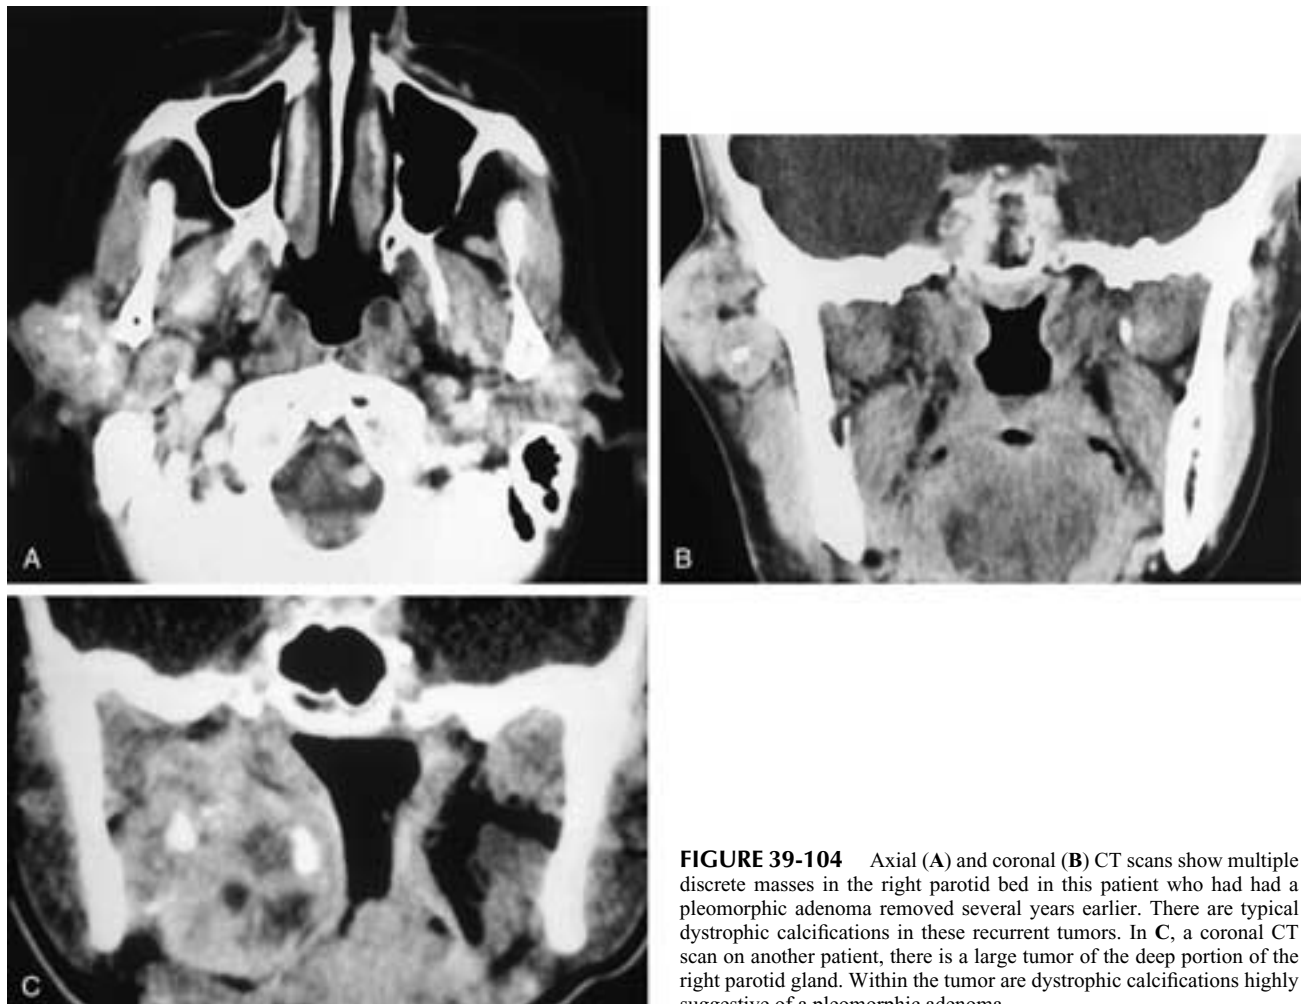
Axial (A) and coronal (B) CT scans show multiple discrete masses in the right parotid bed in this patient who had had a pleomorphic adenoma removed several years earlier. There are typical dystrophic calcifications in these recurrent tumors. In C, a coronal CT scan on another patient, there is a large tumor of the deep portion of the right parotid gland. Within the tumor are dystrophic calcifications highly suggestive of a pleomorphic adenoma.
